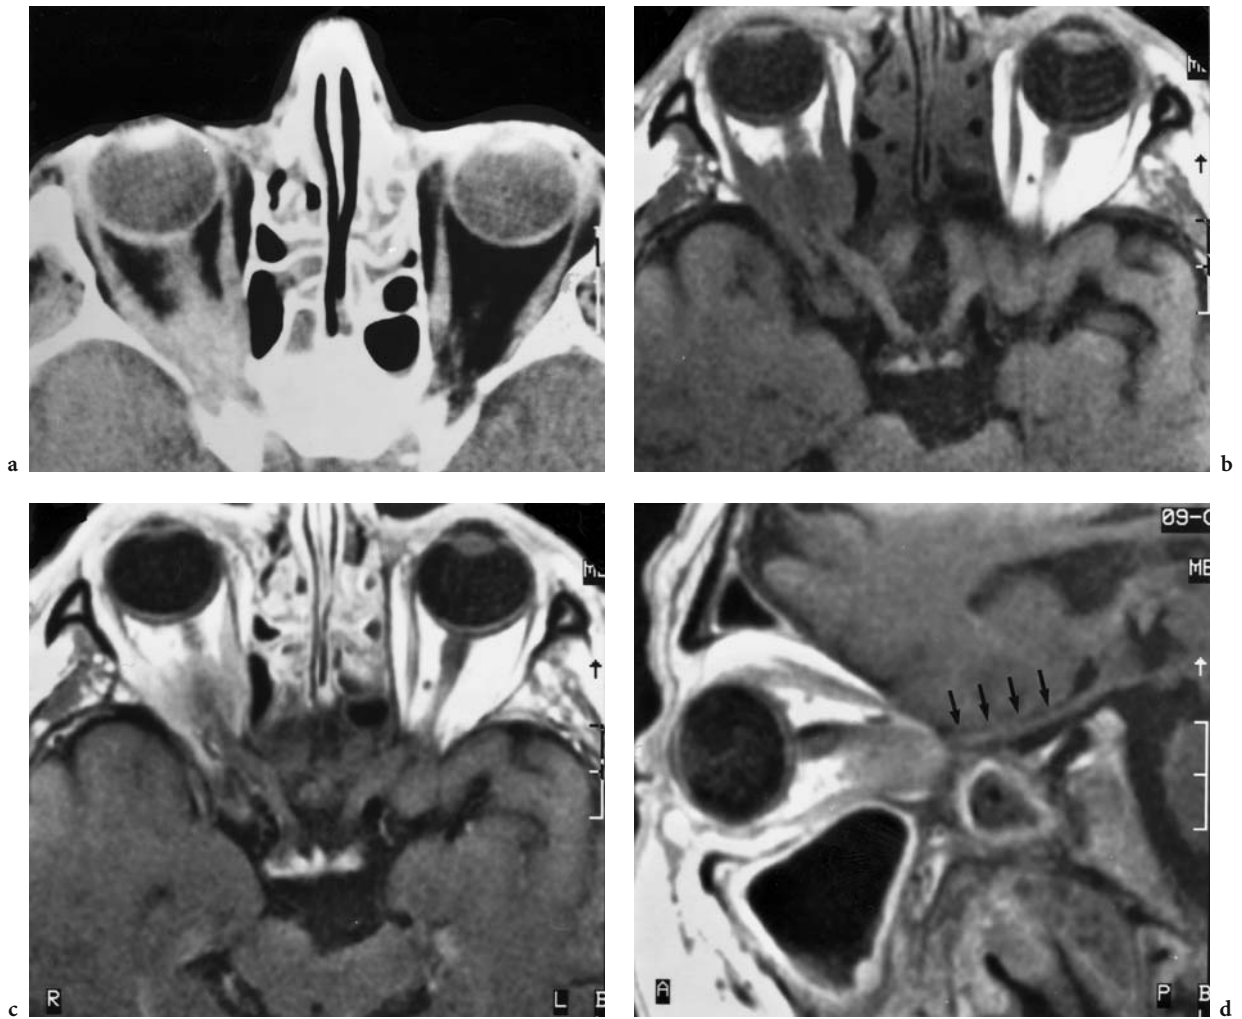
A 61-year-old man with a rapid, progressive visual deficit. Diagnosis: idiopathic orbital inflammatory mass. CT: a Axial contrast-enhanced image, showing an indistinct, space-occupying lesion in the right orbital apex. Apparent infiltration of the optic nerve is likely in view of the poor demarcation of the proximal part. MRI: b Corresponding axial T1-weighted native view with additional infiltration of the enlarged medial and lateral rectus muscles, compared with the left orbit. c Corresponding view after i.v. gadolinium, showing that the entire formation inclusive of the proximal optic sheath exhibits signal enhancement, confirming the inflammatory infiltration. d Parasagittal, T1-weighted, contrast-enhanced view showing the exclusive intraorbital location of the indistinct tumor-like lesion, and providing an overview of the intracanalicular optic nerve and optic tract. (With permission of MÜLLER-FORELL and LIEB 1995b)
